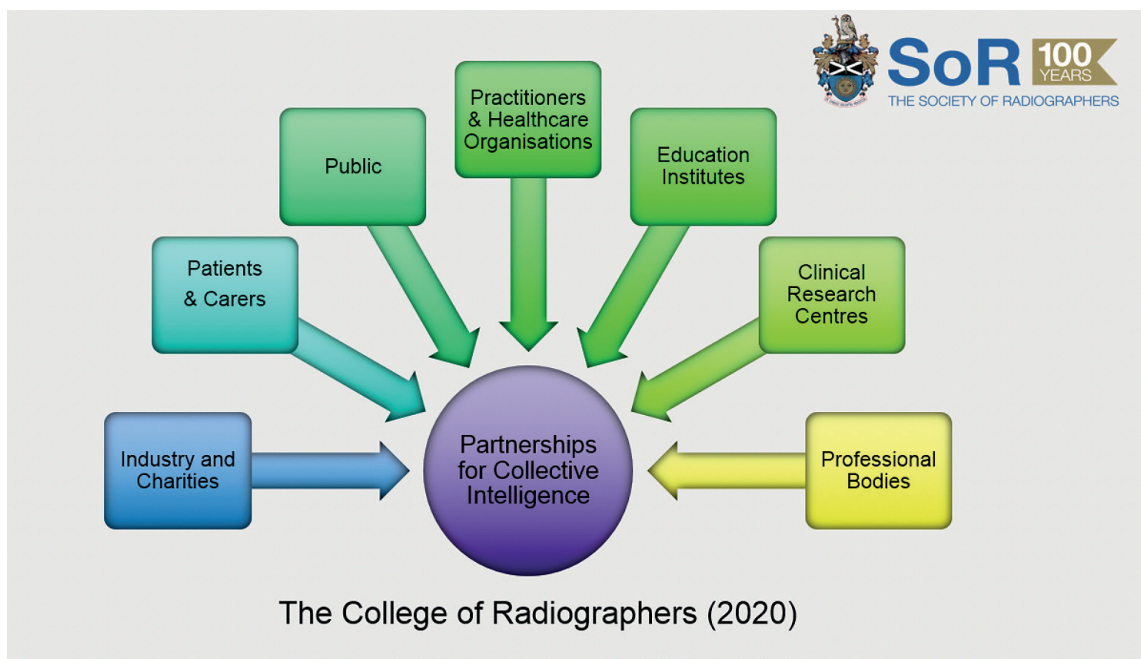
The importance of partnerships in all developments related to clinical service delivery (College of Radiographers, 2020).
